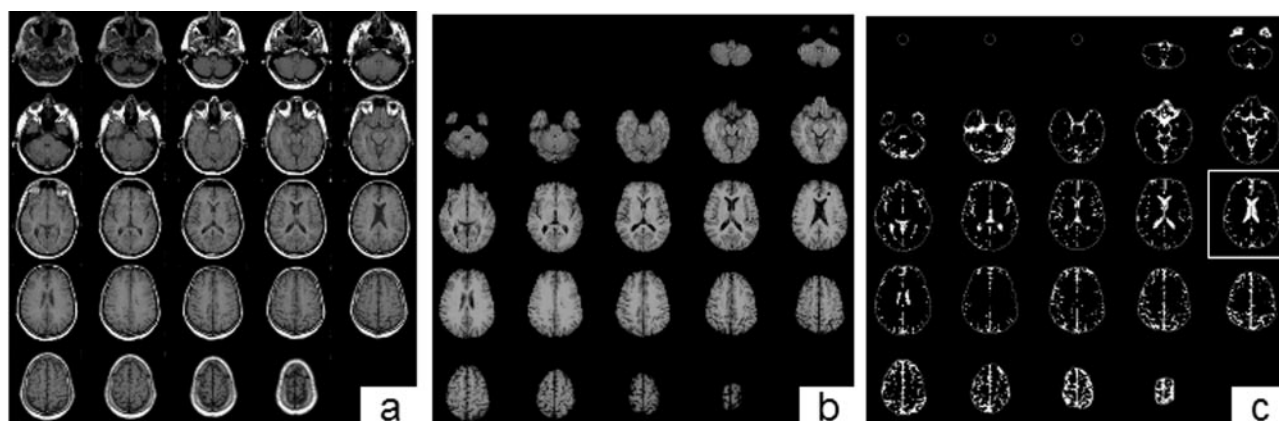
Semiautomated method of obtaining BPF. A, Raw T1-weighted 2D spin-echo noncontrast axial sequence. B, After masking (removal) of extracranial tissue. The segmented image (C) results from separation of the parenchyma (black) and CSF (white) into two compartments. The image surrounded by the white square (C) is used to identify normal-appearing white matter for the thresholding technique (see Methods). Adapted from Bermel et al (25).
